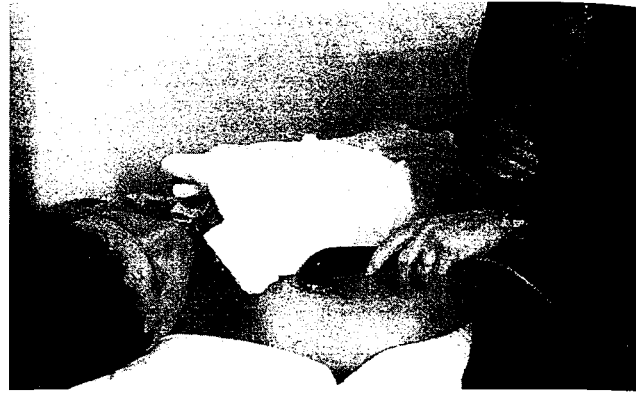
Ultrasound applied to the anterior aspect of the shoulder for treatment of adhesive capsulitis*
